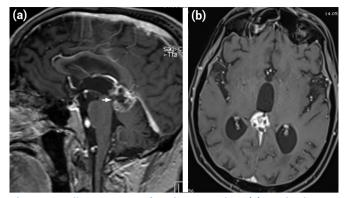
Follow-up MRI after the operation. (a) Sagittal postcontrast T1-weighted image shows heterogeneous enhancement of the pineal mass (white arrow indicates biopsy site) (b) Axial postcontrast T1-weighted MRI shows the pineal mass (arrow) and the ventricles (arrowhead)reduced in size after endoscopic third ventriculostomy. By this stage, the patient had undergone radiotherapy and chemotherapy, and the images demonstrates the stable disease.
